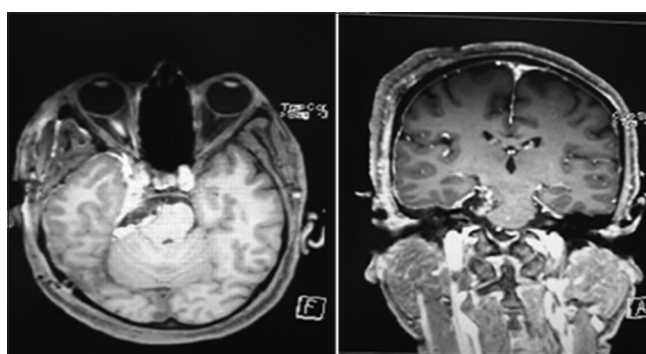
Postoperative MRI brain (axial and coronal) with contrast after lesion resection
